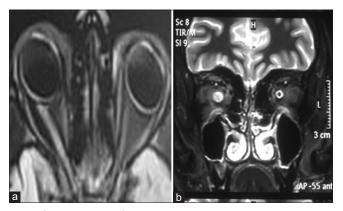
(a) MRI orbit T2W axial image showing right anterior segment longitudinally extensive hyperintense signal in the optic nerve. (b) MRI orbit STIR coronal image showing perineurial optic nerve sheath enhancement in right optic nerve in MOG antibody positive patient
